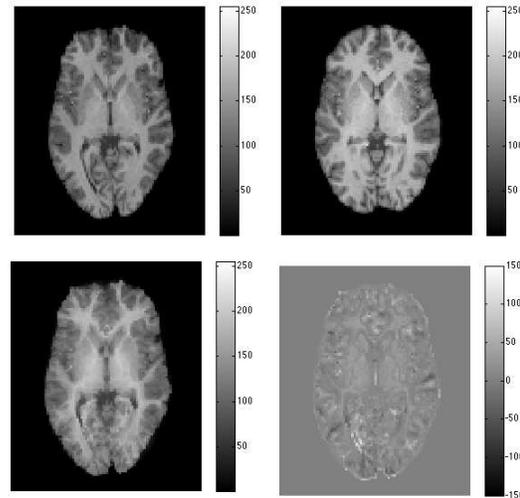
Registration of a typical healthy subjects brain MRI top left to that of another subject top right. Axial sections through the warped image bottom left and the difference image after registration bottom right indicate the registration accuracy.
